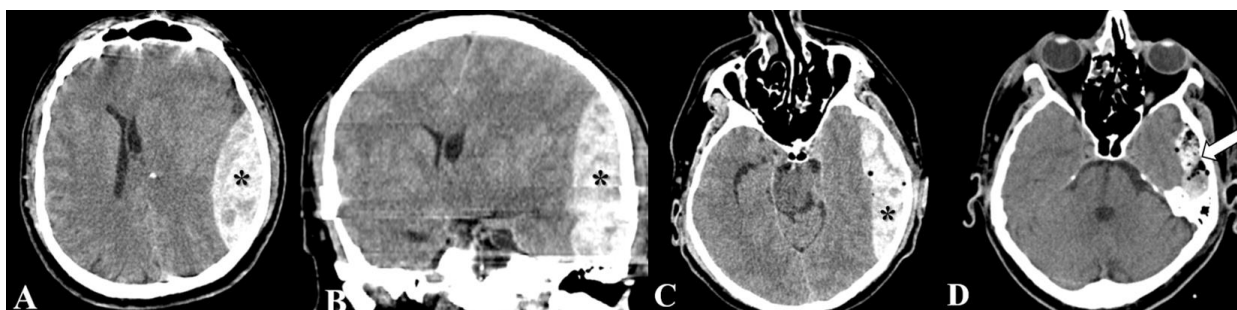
Preoperative cranial CT scan with left temporal extradural hematoma (*) (A, B, C). Postoperative cranial CT scan showing temporal muscle left *in situ* (white arrow) (D)
